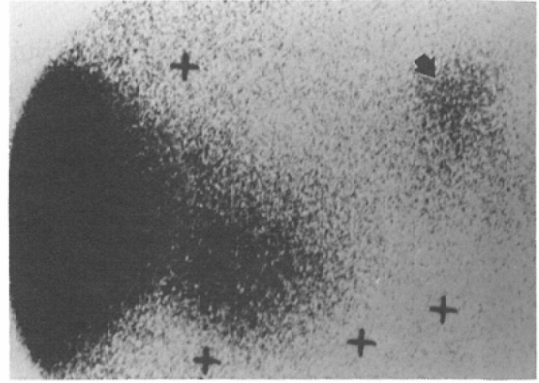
Liver scintigram (anterior view). Uptake area to the left of the liver (arrow). Preoperatively, this uptake was regarded as that of the spleen.
